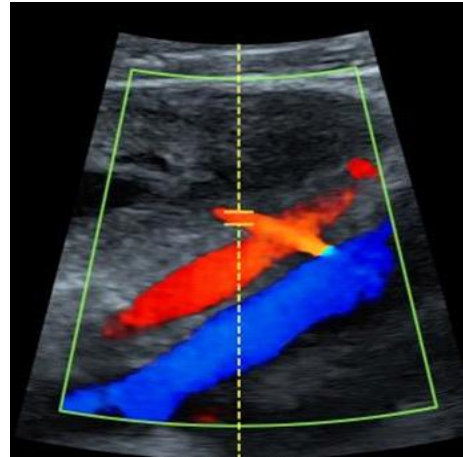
Doppler image of uterine artery at crossover iliac artery
